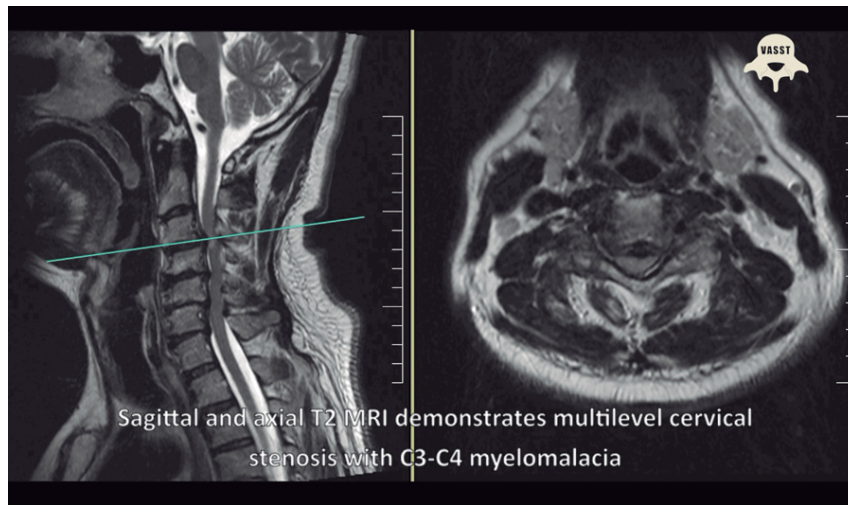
Preoperative MRI demonstrates spondylotic cervical myelopathy.
